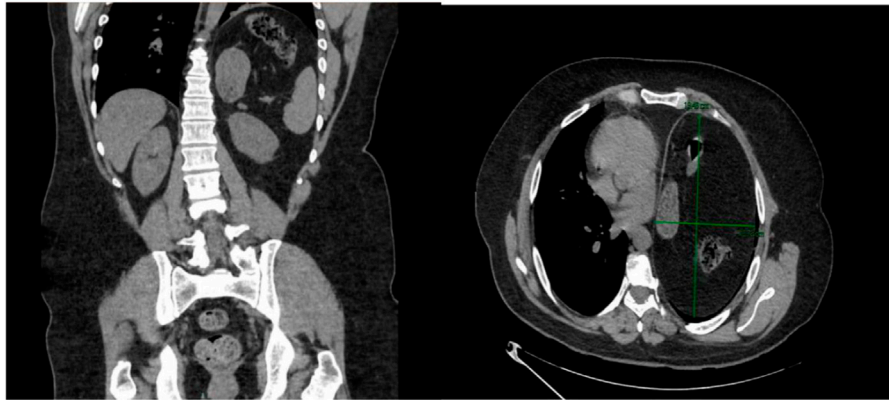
Computed tomography scan (coronal and transverse section). Significant elevation of the left hemidiaphragm and infradiaphragmatic abdominal contents, including the stomach, spleen, and splenic flexure of the colon and deviation of the mediastinum to the right.
